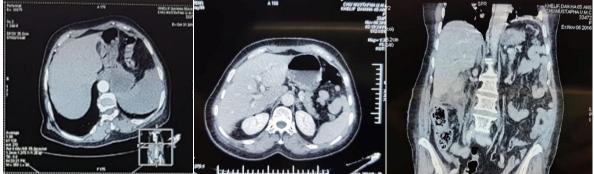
CT scan after 48 months
